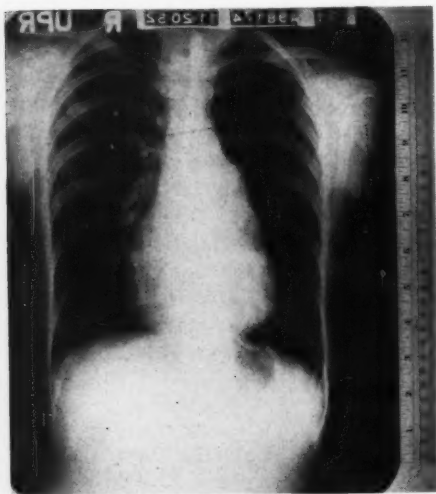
Chest x-ray film in M. E. C., an instance of interatrial septal defect with Marfan's disease.
